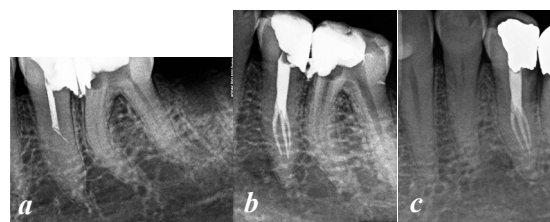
Third case of retreatment of #35: (a) preoperative, (b) final and (c) 9 months control radiographs. The cervical part of the root canal appears to be very wide until the point of trifurcation. Healthy periapical conditions after 9 months of the endodontic retreatment of the tooth are observed
